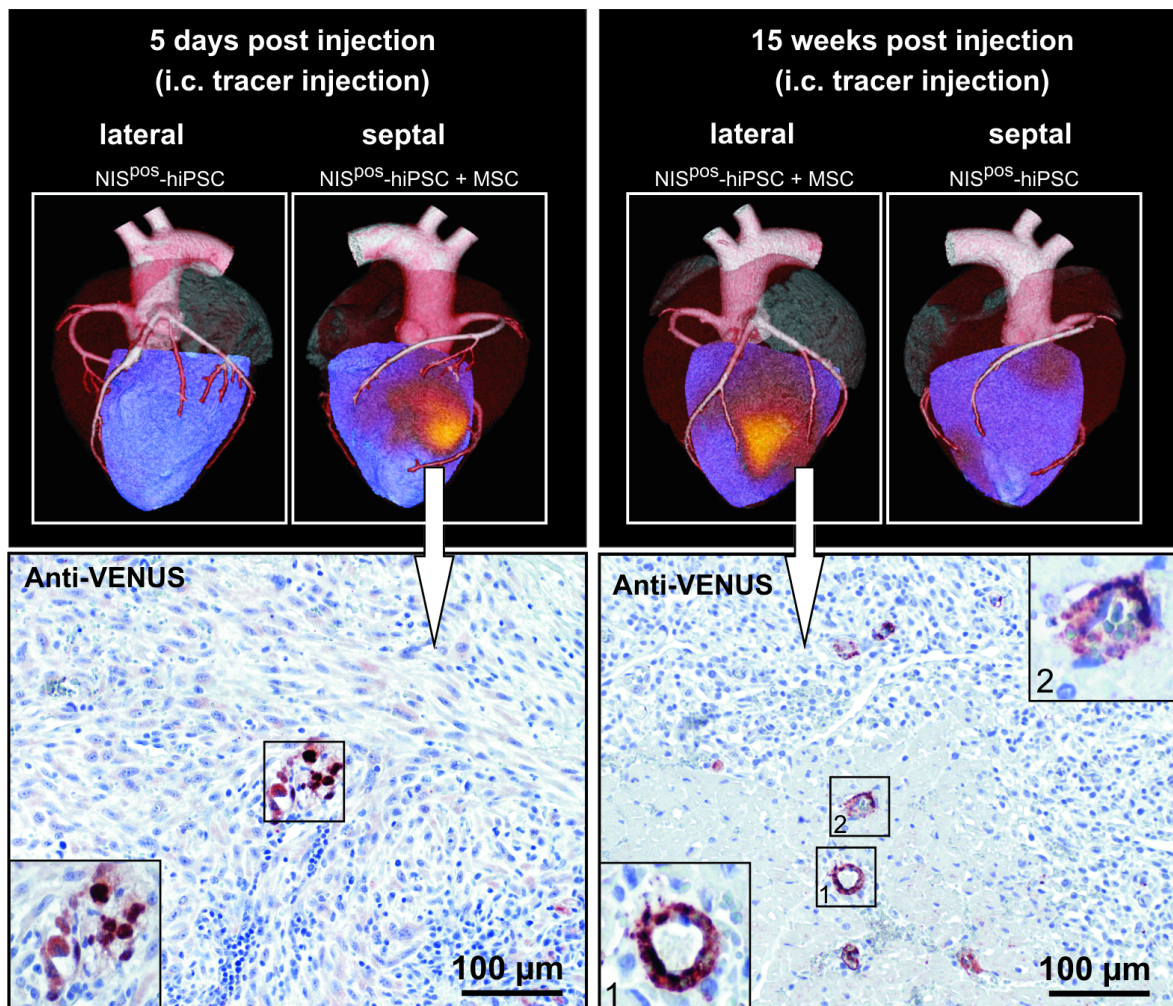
In vivo* Hybrid-SPECT-CT Imaging zur Detektion des Langzeitüberlebens NIS^+ -hiPSC
